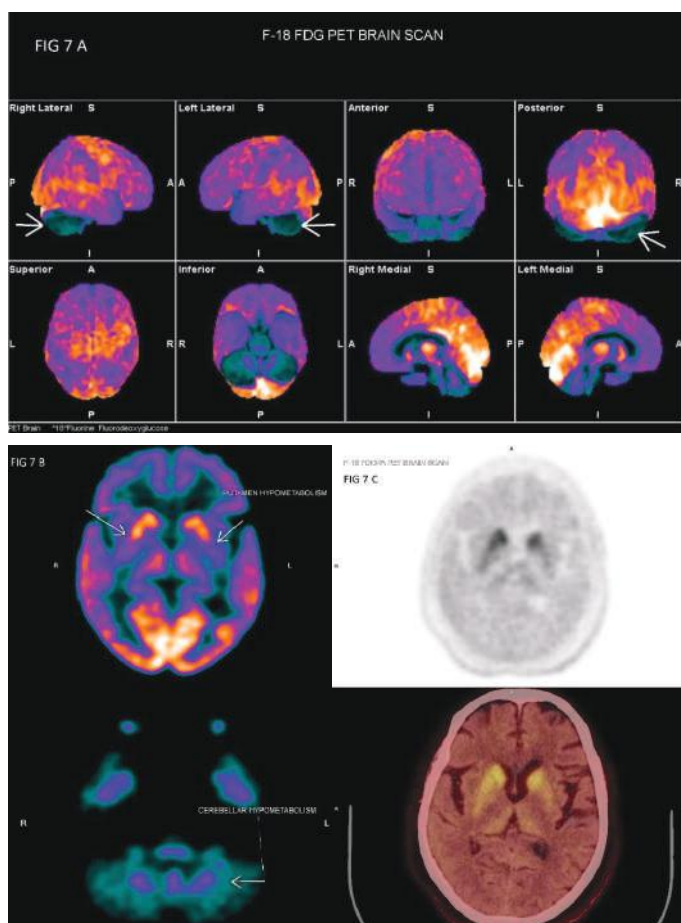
FDG PET scan (fig. 7a & 7b) findings showed severe hypo metabolism involving bilateral basal ganglia (putamen much more than caudate) and bilateral cerebellar hemispheres (white arrows). FDOPA scan (fig. 7c) findings demonstrated reduced dopamine concentration in bilateral basal ganglia with putamen more severely affected than the caudate. She was diagnosed with Multisystem atrophy or MSA. She was started on Syndopa plus. Her course was stable at the time of collection of data for this review.
